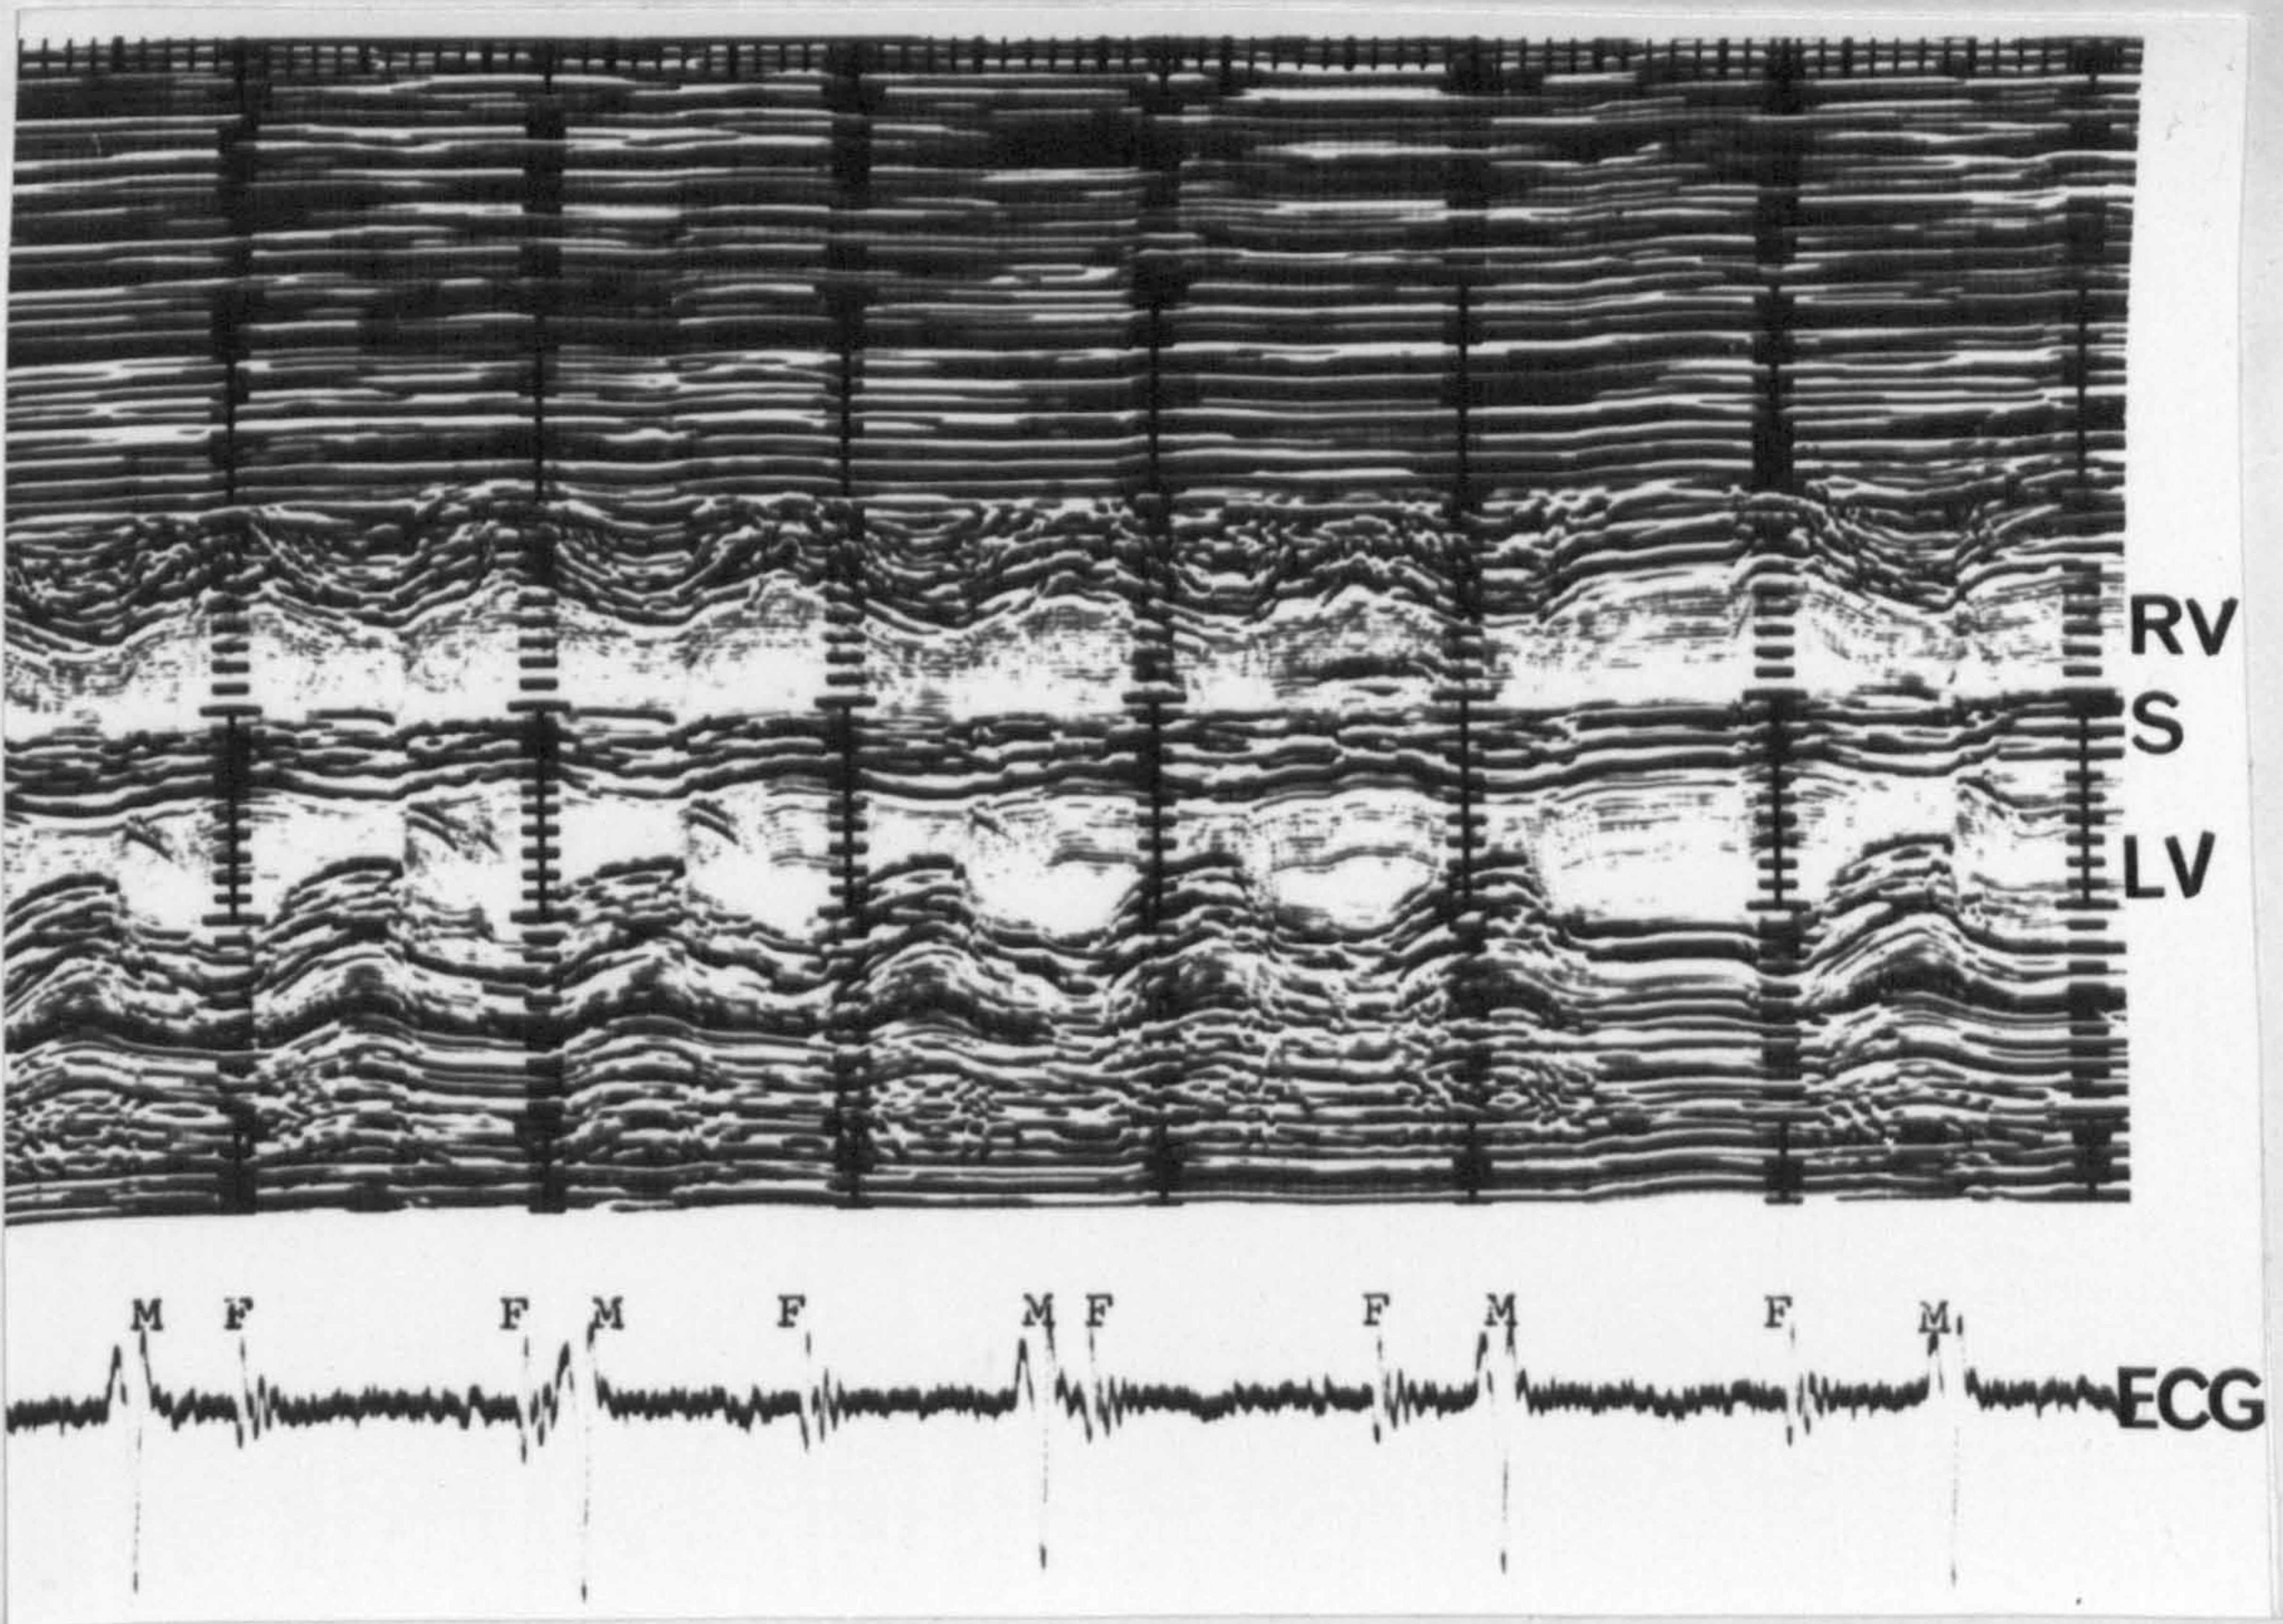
The M mode echocardiogram is taken across both ventricular chambers just below the mitral valve. The right ventricle is superior to the left.
